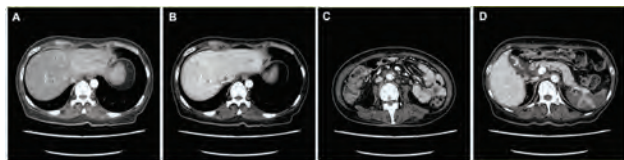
CT findings of hepatic nodules in (A) Arterial and (B) Venous phase indicating liver involvement of PTLD. (C) PTLD with lymph node and (D) splenic involvement.
